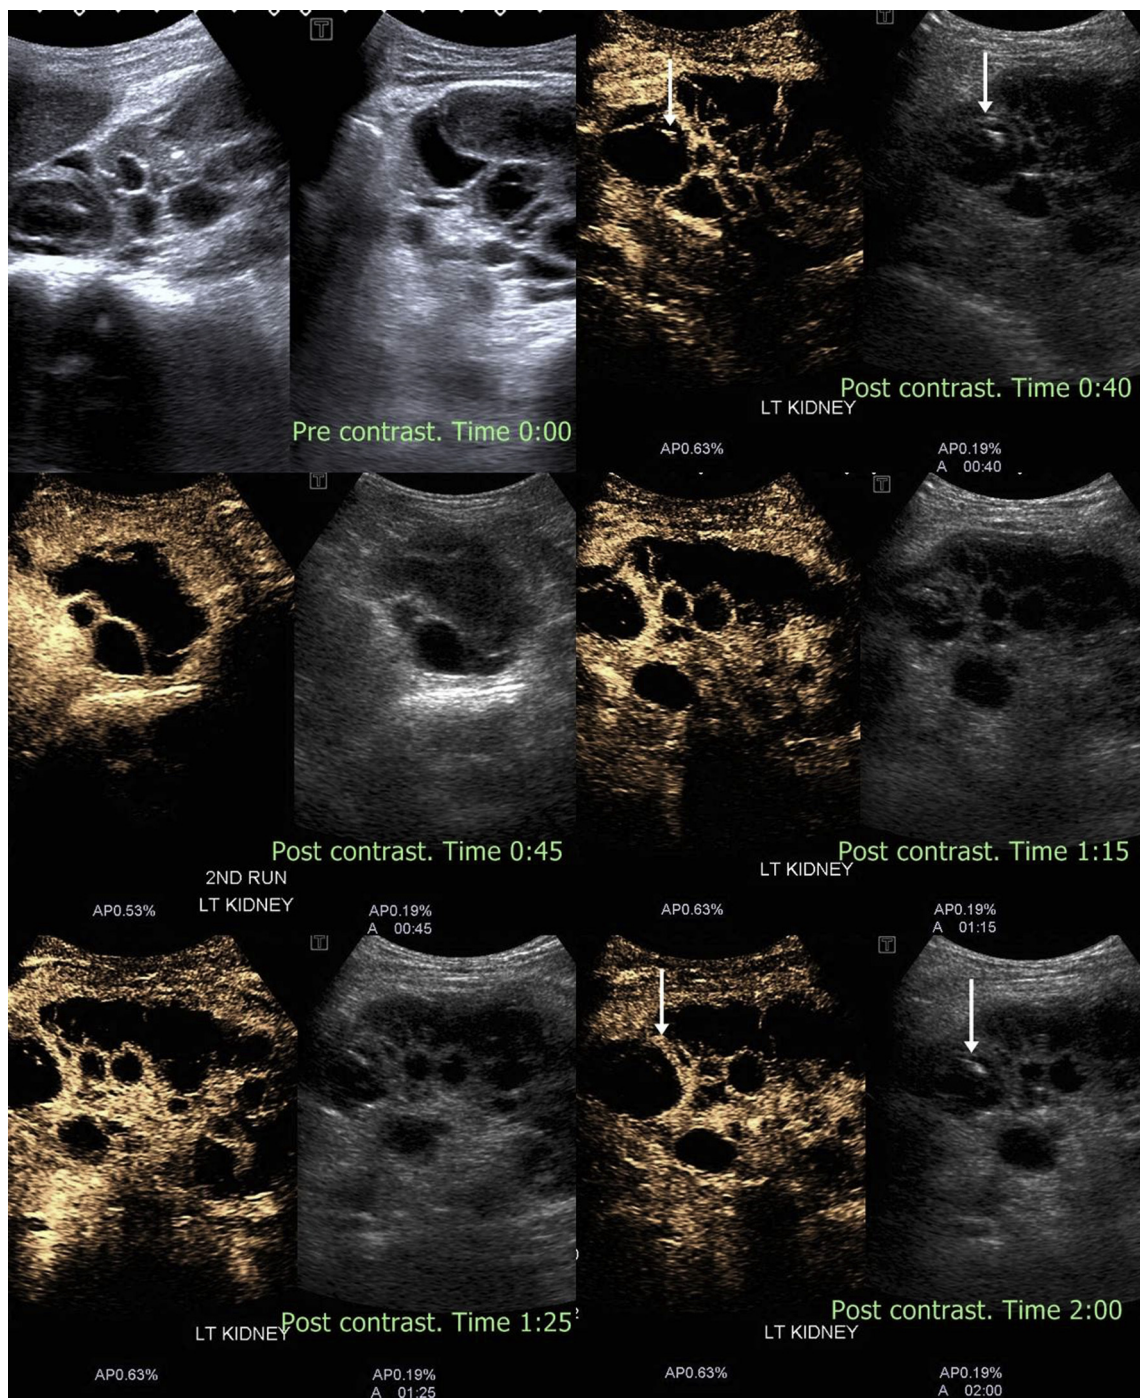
Complex renal cyst. Noncontrast ultrasound shows a large renal cyst with solid echogenic component within the cyst. Post-contrast images show no intracystic enhancement and the apparent echogenic solid lesion (white arrow) shows no arterial enhancement or washout. It was proven on follow-up imaging to be a complicated cyst with some internal hemorrhage.
